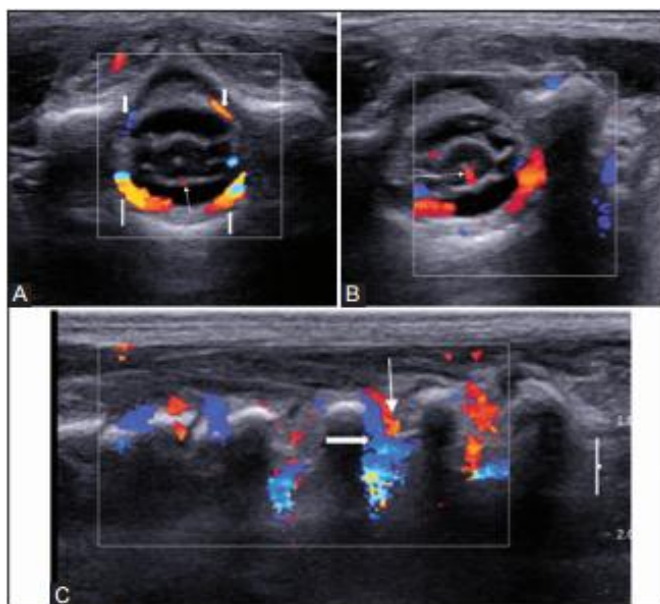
(A-C): (A-C) Doppler USG of normal thoracic spine. Axial images with Doppler interrogation (A, B) show the anterior spinal artery (arrow in A); the sulco-commisural artery (arrow in B) and the ventral and dorsal dural arcades (block arrows). The parasagittal image (C) reveals the dorsal division of the dorsal spinal artery (arrow) with accompanying vein (block arrow) arising from the segmental arteries at multiple levels
